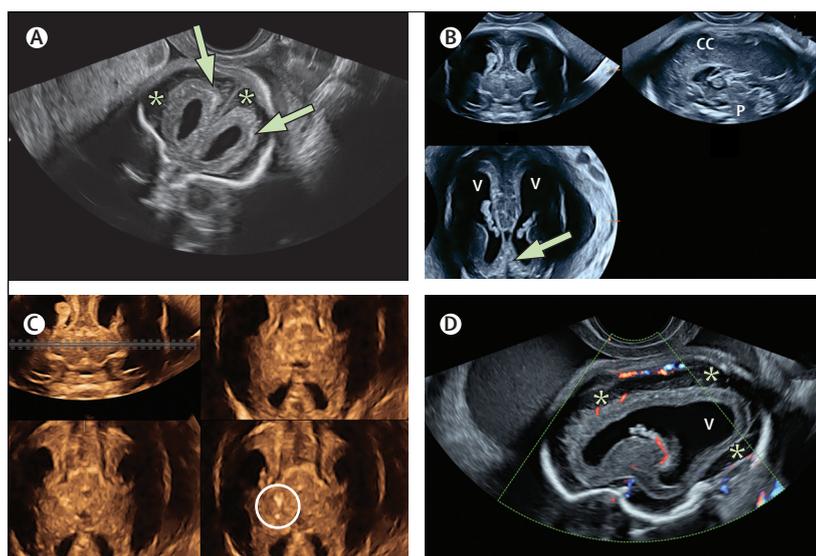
Fetal anomalies observed by ultrasound
